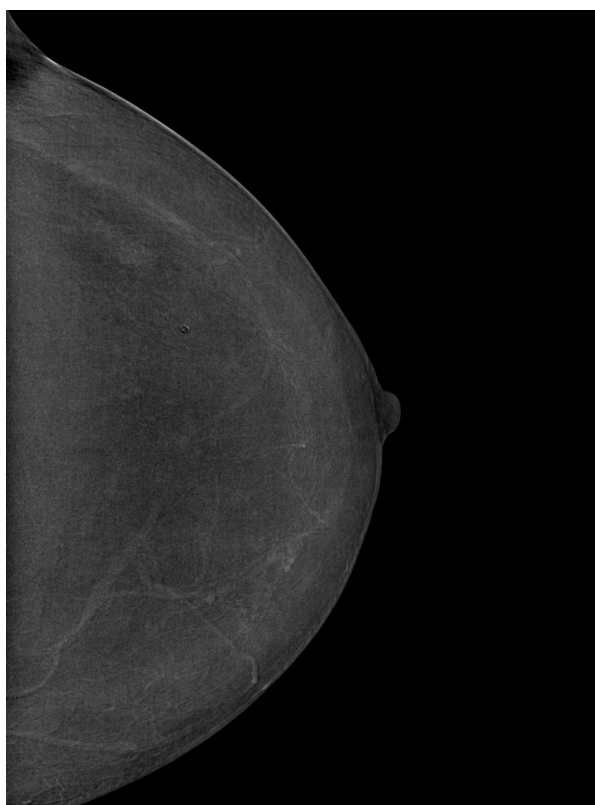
Contrast-enhanced dual-energy mammography (CEM) with a second-look ultrasound was performed. CEM demonstrated a subtle area of contrast enhancement at the same site as the MRI finding, with no correlating abnormalities on ultrasound.
